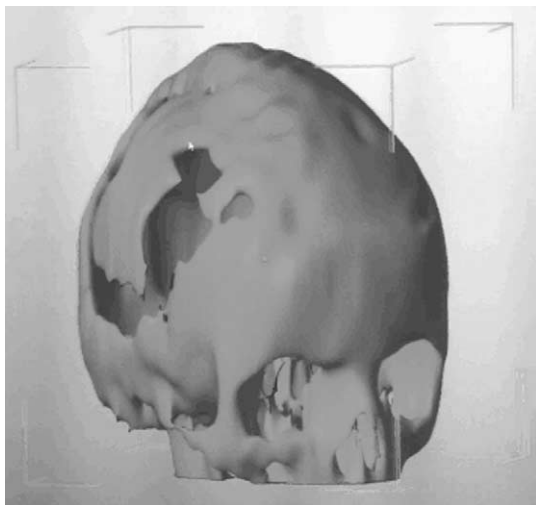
Three-dimensional model file, created from CT image data, ready to be sent to 3D printer.
